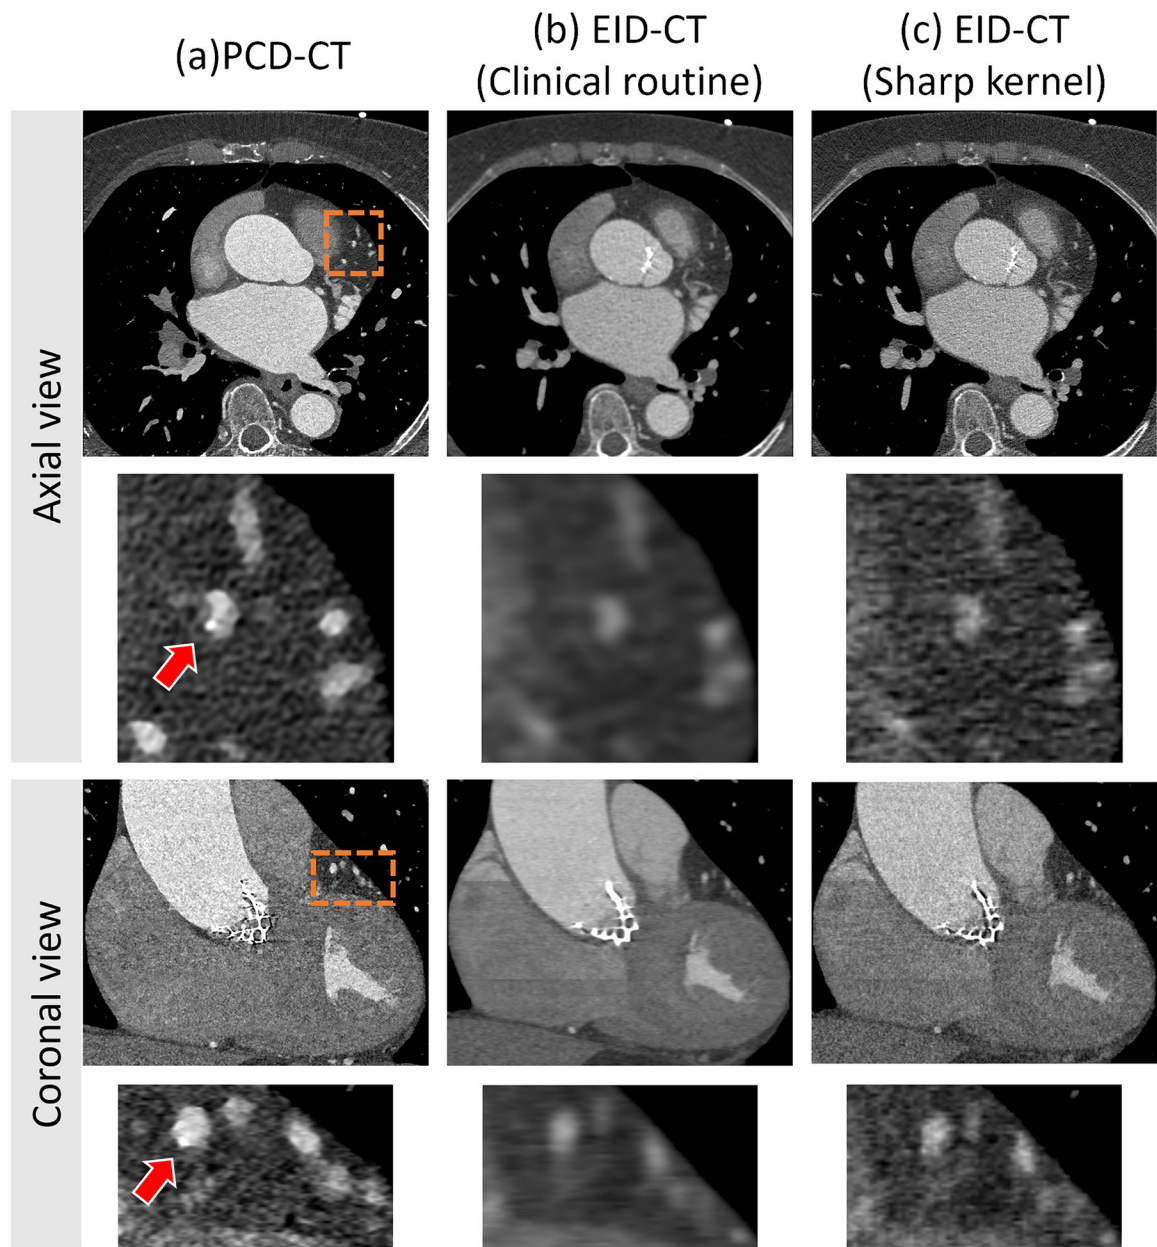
Sample images of small calcium detection in patients. Axial and coronal view of PCD UHR (a), EID-clinical routine (b), and EID-sharp kernel (c) CT images of a coronary CTA in a 77-year-old man show that high spatial resolution enabled detection of the very small calcification (arrow in (a)). Image display window (WL/WW: 200/1000 HU).
